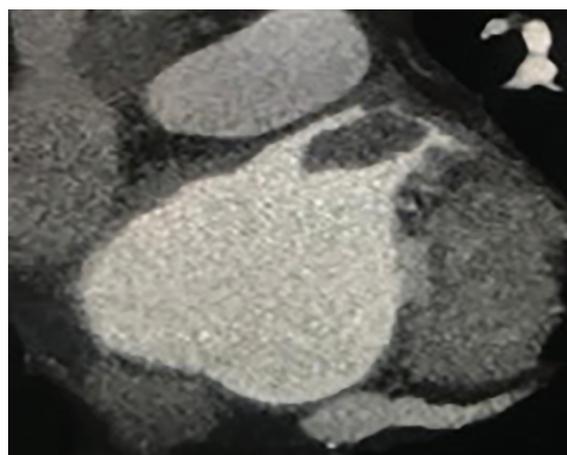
LAA thrombus detected by CT
